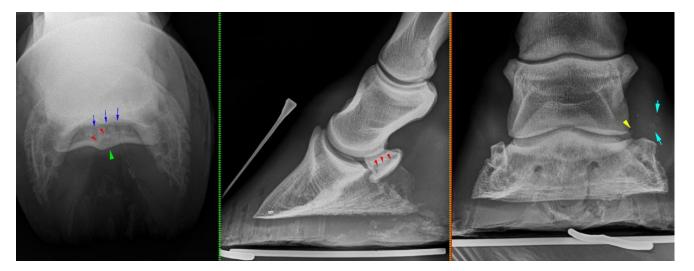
Labelled PaPrPaDiO, LM and DP radiographs of the left front foot. Blue arrows indicate enlargement of the synovial invaginations. The concave lucency in the flexor cortex and extending into the spongiosa (green arrowhead) is bordered by sclerosis (red arrowheads). Smooth enthesophytosis is present on the medial and lateral aspect of the proximal navicular bone margins (yellow arrowhead). Small mineral bodies are present in the lateral soft tissues, most consistent with separate centers of ossification or partial ossification of the ungual cartilage (light blue arrows).
